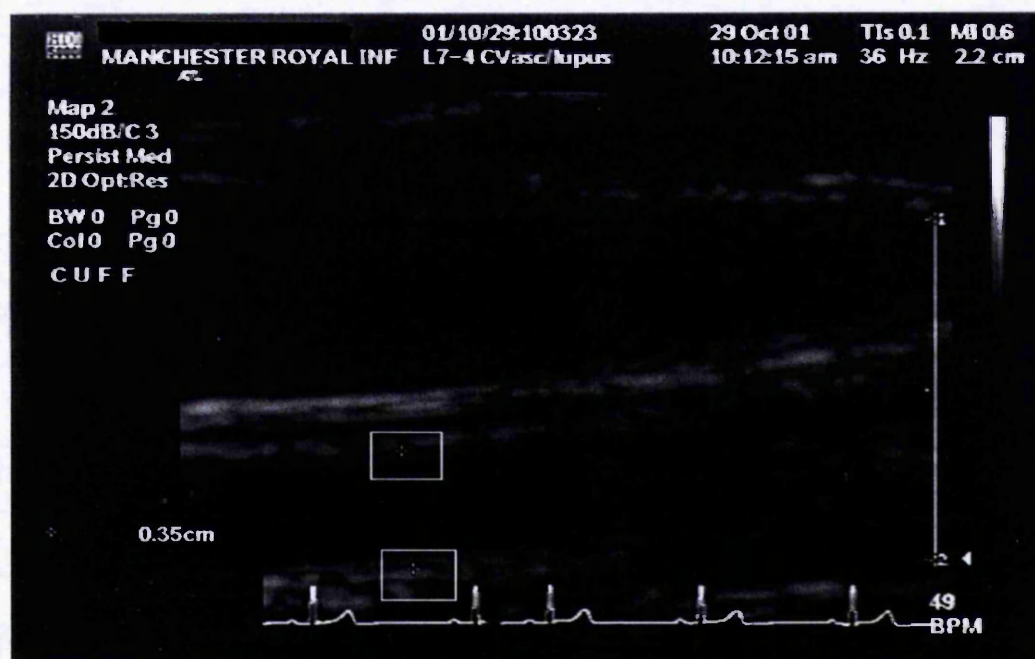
Ultrasound image of the resting diameter.
